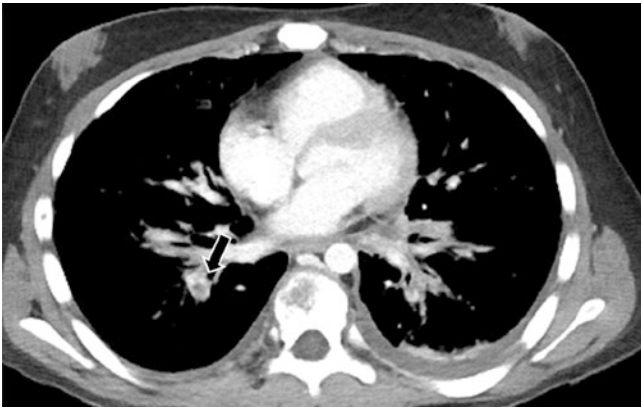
Incidental PE in a 13-year-old boy with metastatic adenocarcinoma, unknown primary, who presented with dyspnea and left shoulder pain. Axial image from a routine contrast-enhanced CT chest demonstrates an expansile filling defect (arrow) in a right lower lobe segmental pulmonary artery. Trace right and small left pleural effusions are also visualized. Bilateral gynecomastia is also incidentally noted
